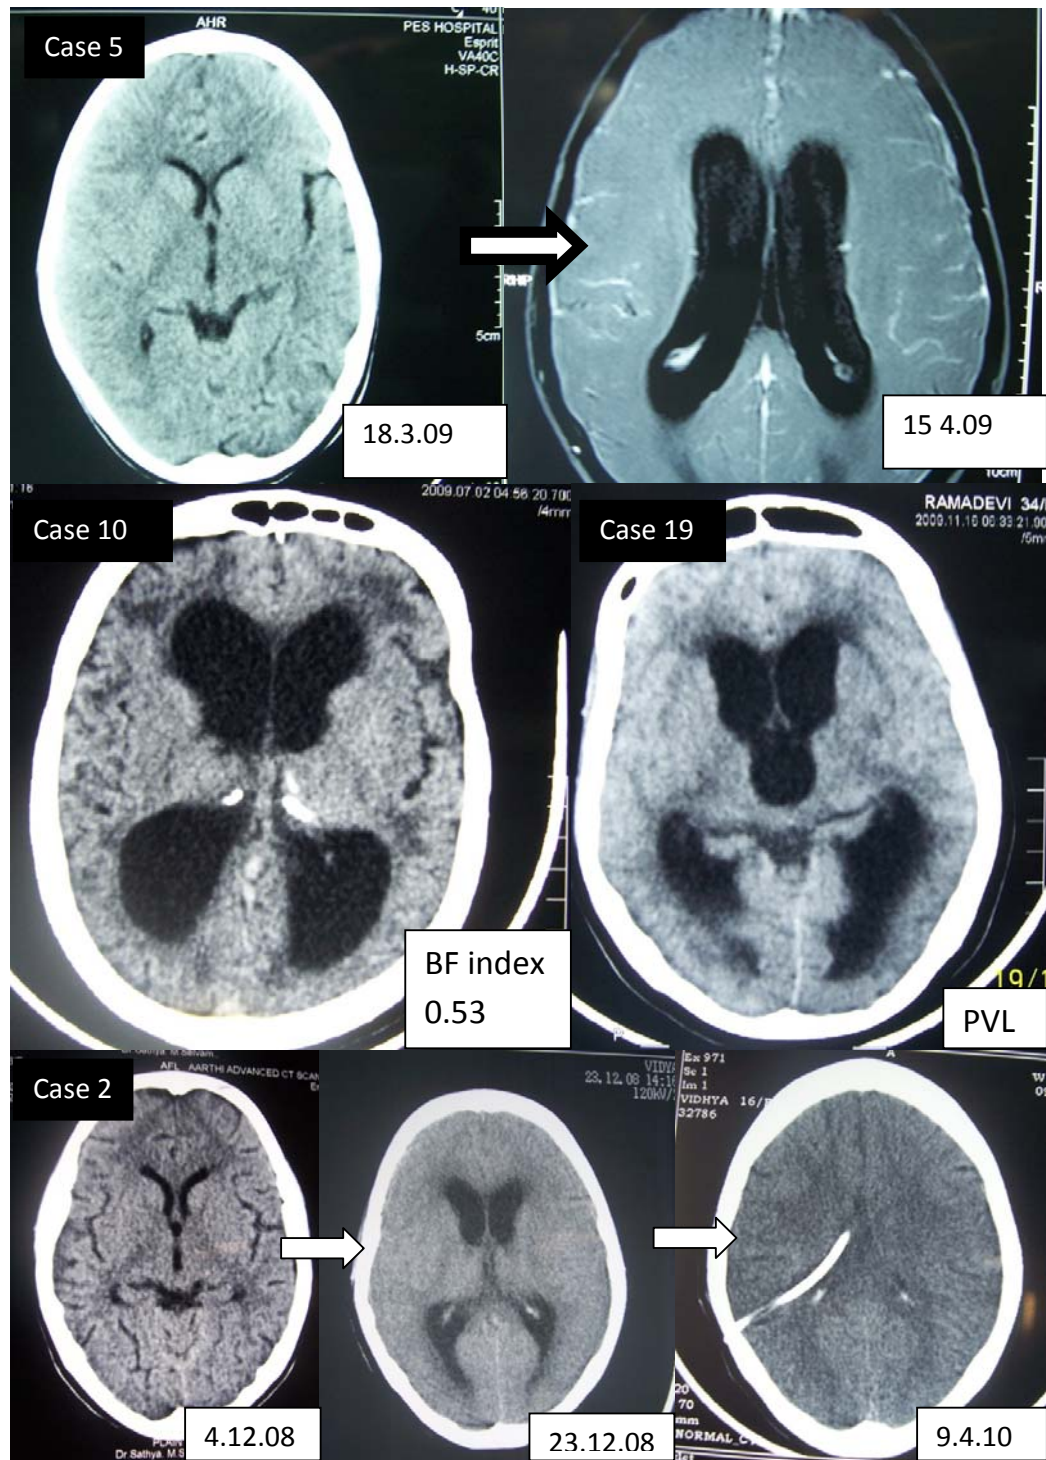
CT Brain - Post meningitic hydrocephalus
